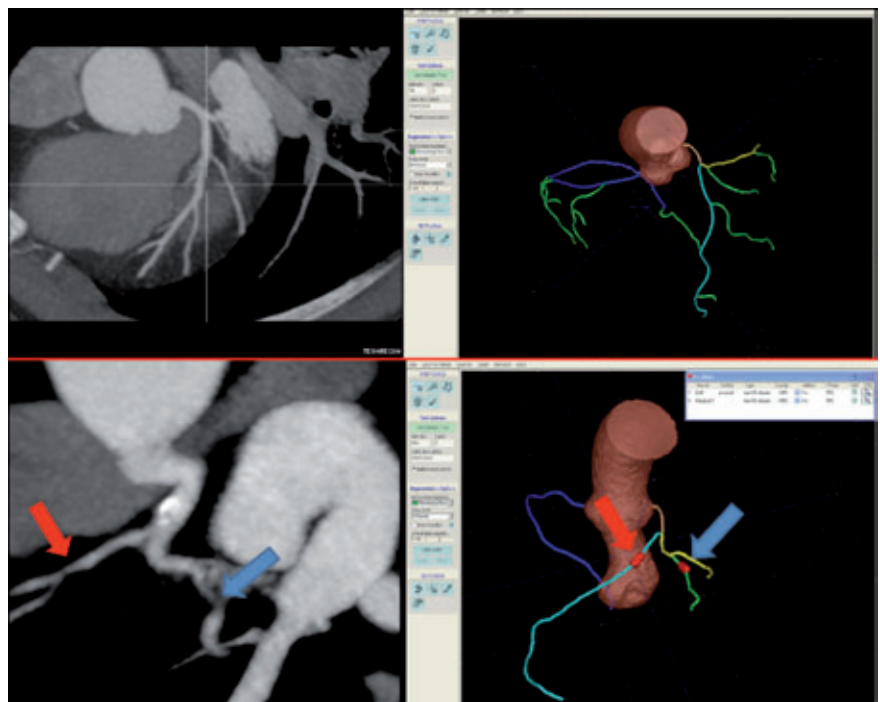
(Upper panels) MIP of a normal coronary computed tomography angiography (left) and a normal Rcadia computer-aided diagnosis image output (right) of the same patient. (Lower panels) MIP (left) and Rcadia computer-aided diagnosis image and findings output (right) of a coronary computed tomography angiography with 2-vessel non-calcified obstructive (>50% stenosis) disease. Red arrows point to the proximal LAD lesion and blue arrows point to the OM branch lesion.
